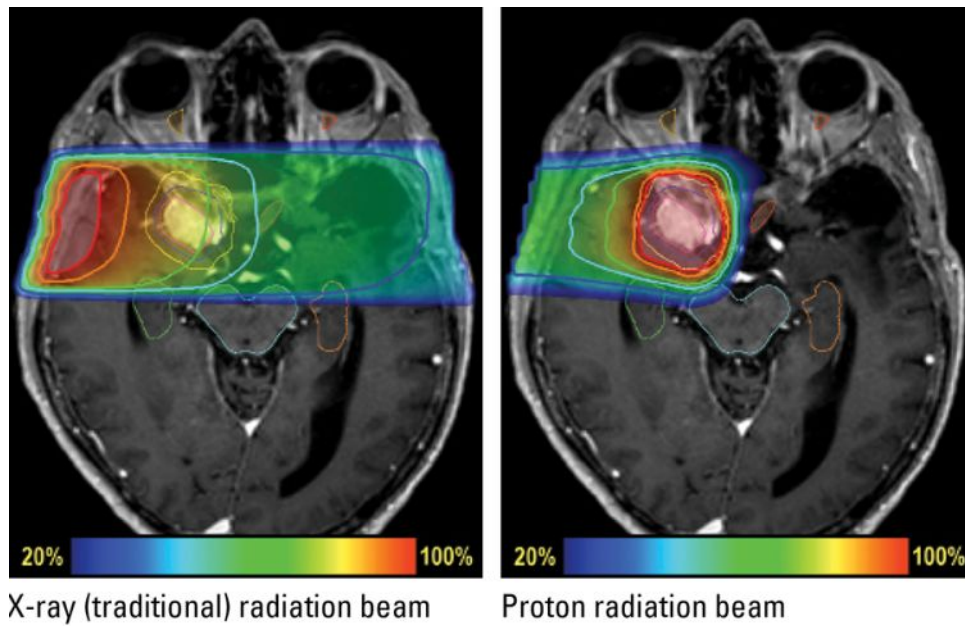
Dose deposition on MRI image for a patient with meningioma (17)
